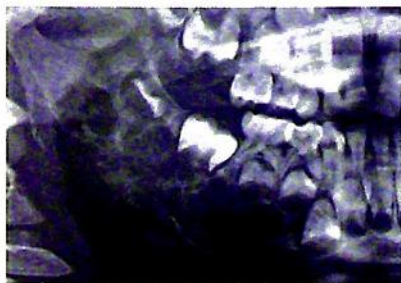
The diagnosis of a multilocular or soap-bubble lesion must always be treated with concern. These are invasive lesions and prompt referral is necessary. (A) Desmoplastic fibroma of the right mandible. (B) A large rhabdomyosarcoma involving the ramus of the right mandible and infratemporal fossa the extent of which is visible on the CT scan (C).
